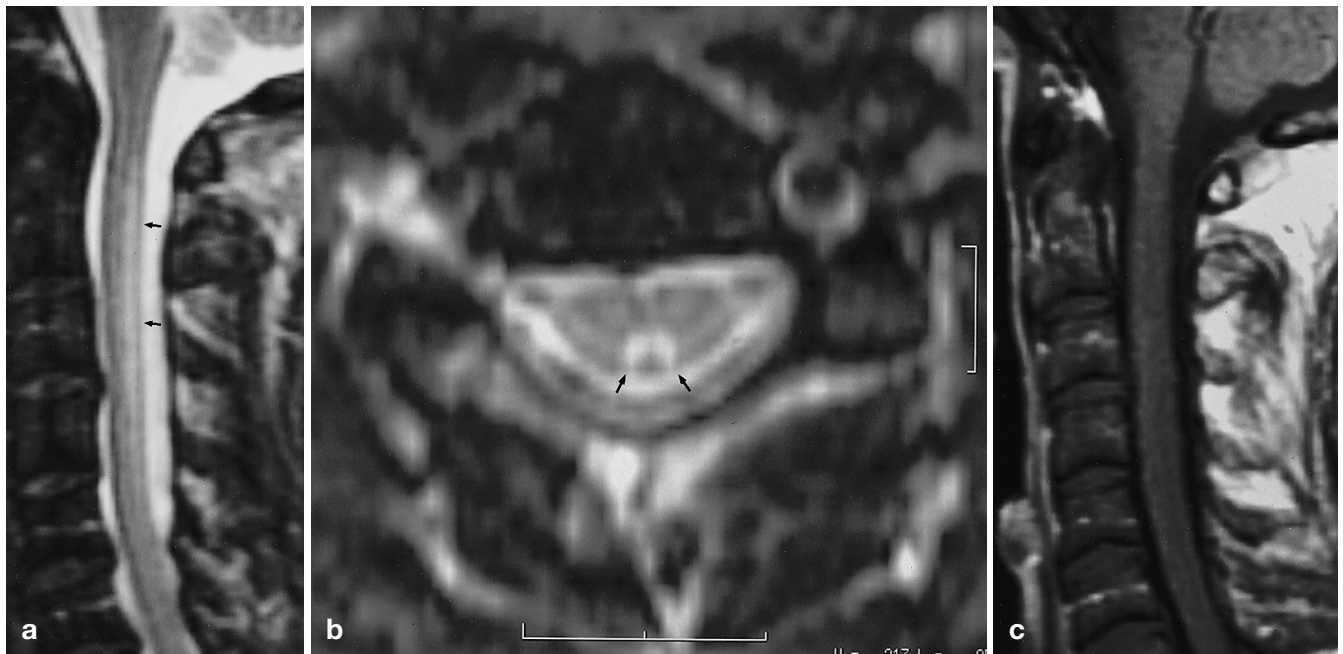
T2-weighted sagittal a and axial b and sagittal contrast-enhanced T1-weighted c images of the cervical spinal cord; non-enhancing symmetrical triangular high-signal lesions in the posterior columns, especially in the gracile tracts (*arrows*), without mass effect
